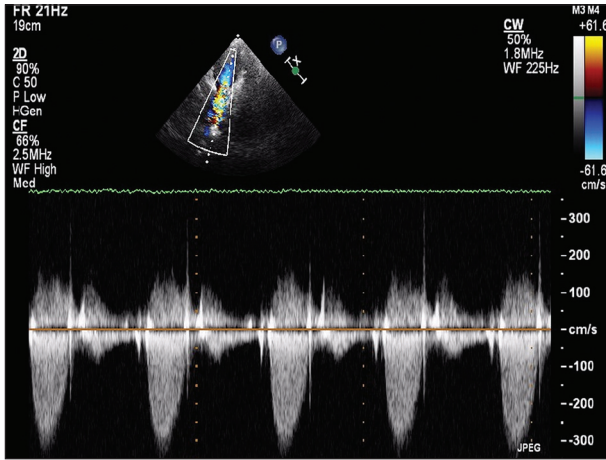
The interrogation of aortic valve using 2D echocardiograph with continuous wave Doppler in long axis view with a swipe to base to focuses aortic valve. The peak gradient across aortic valve is less than 30 mmHg without any aortic regurgitation after 1 month of percutaneous aortic valve dilatation. The peak gradient across aortic valve was 75-80 mmHg prior to the procedure
